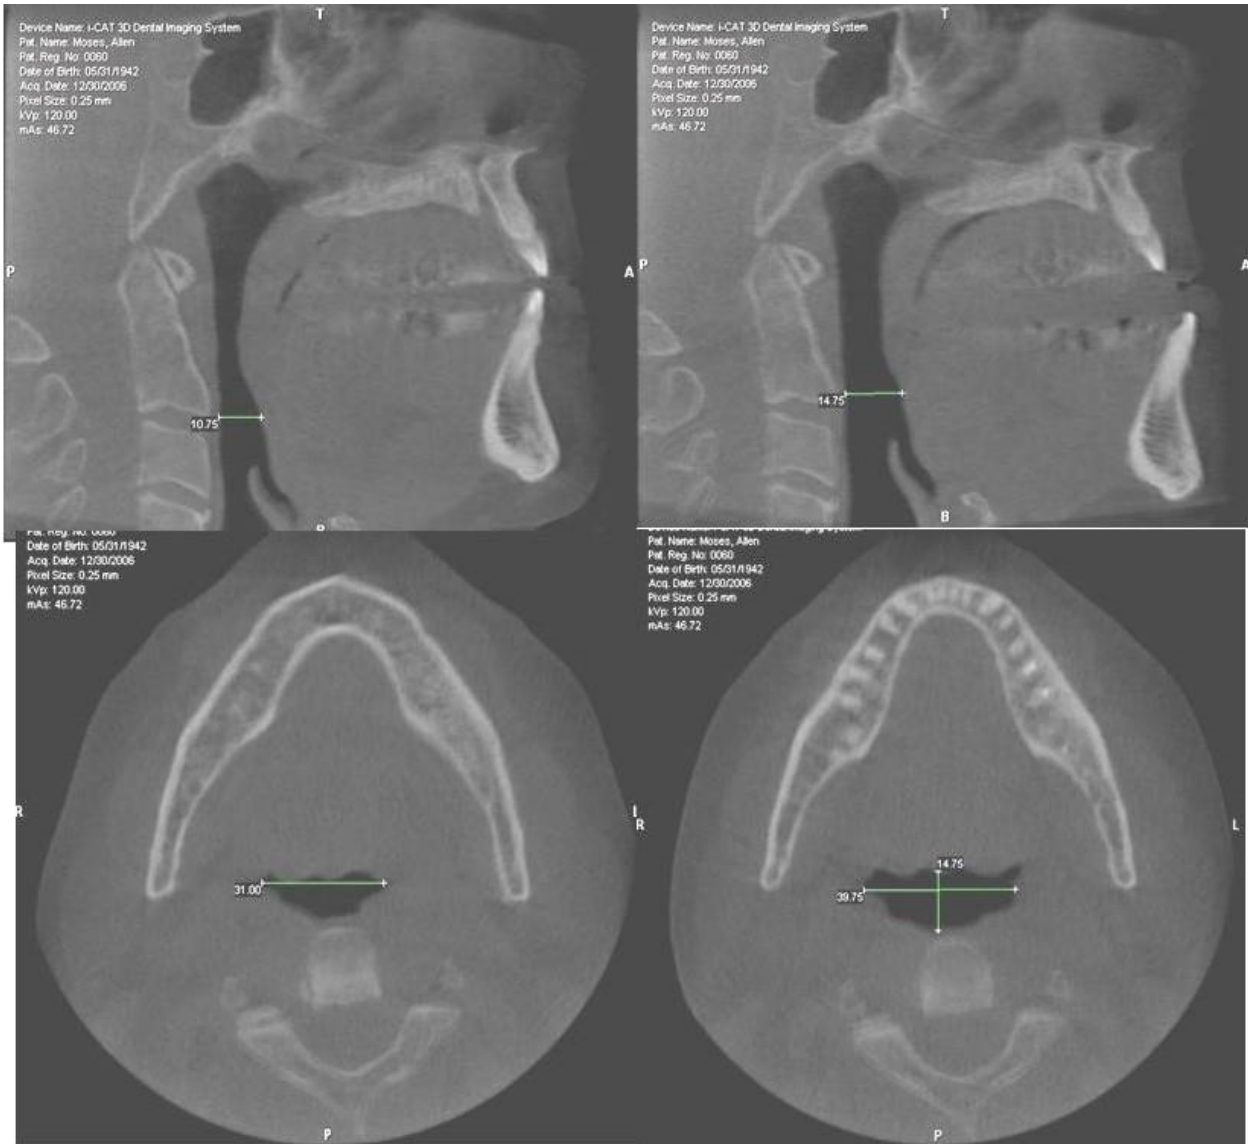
Lateral and coronal views of CT Scan demonstrating enlargement of airway using the same oral device as in Fig. 2.
